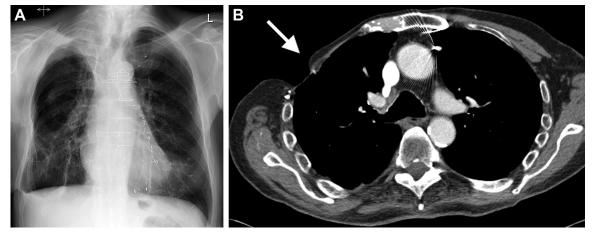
A, Posterior-anterior chest radiograph in 91-y-old man showing relative hyperlucency in the right mid- to upper zones (arrow). B, Axial CT image on soft tissue windows showing prior surgical resection of the right pectoral muscles and chest wall fat (arrow) for use as myocutaneous flap graft.
